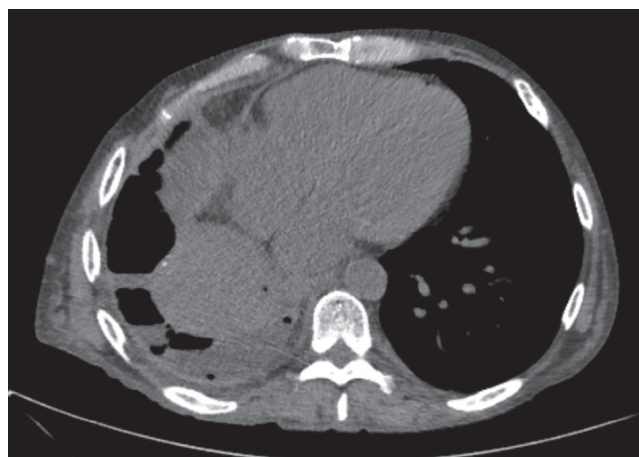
■ CT scan showing an uneven, lobulated, circumferential effusion suggesting the presence of a thickened visceral peel that requires operative drainage and decortication.
